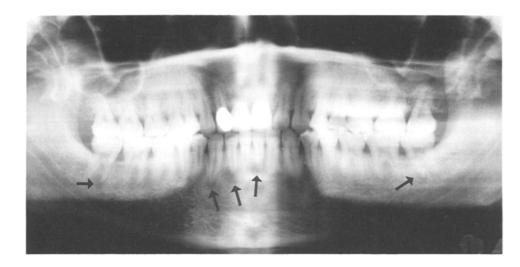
Orthopantomograph of the probands son (II-2, Fig. 3) showing multiple periapical radiolucent lesions (*arrows*), mostly in the lower incisor region
